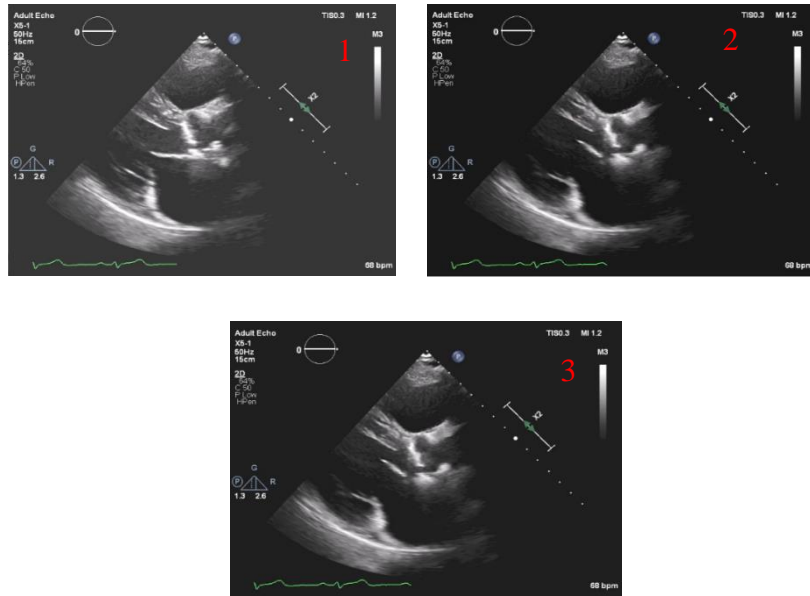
Echocardiography examples with different Window Levels (WL) and fixed Window Width of 250 (1) WL= 75, (2) WL = 100, and finally, (3) WL = 125
